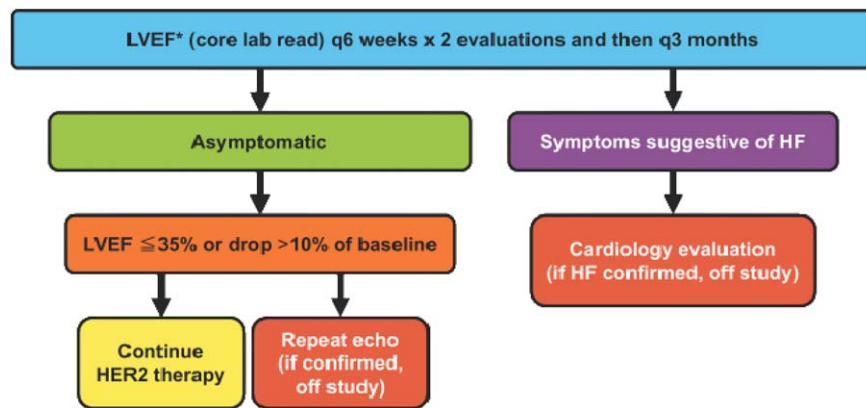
Cardiac monitoring. Echocardiograms will be performed at baseline and after starting HER2 targeted therapy every 6 weeks for 2 assessments and then every 3 months while in the study. All echocardiograms will be analyzed by an independent investigator at the Core Lab blinded to any clinical data and following standard procedures as recommended by the American Society of Echocardiography, and results will be used to determine when HER2 targeted therapy should be held, rechallenged, or stopped.
